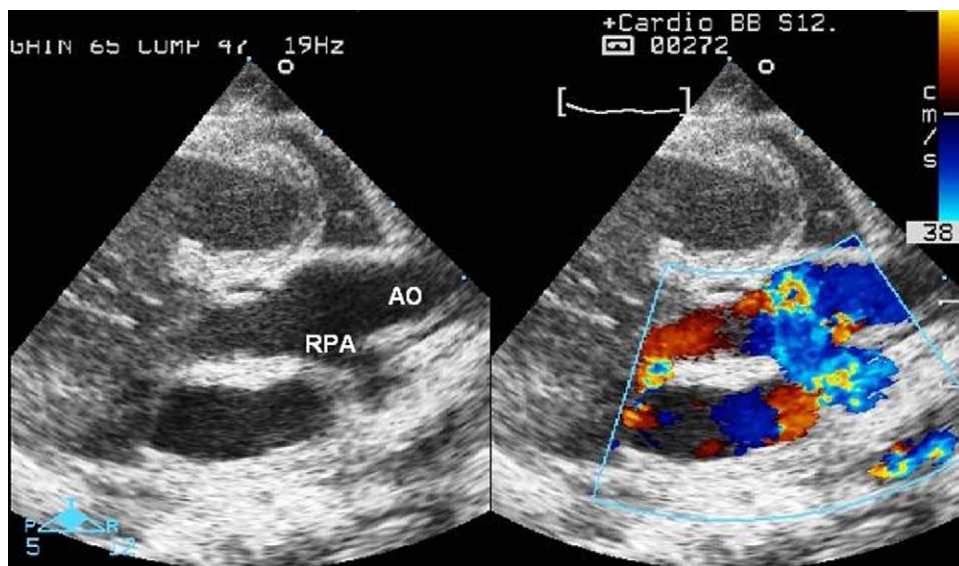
Parasternal long-axis view without (left) and with colour Doppler (right). The right pulmonary artery arises from the posterior wall of the aorta. The colour Doppler scan shows the massive shunt into the right pulmonary branch. Ao: aorta; RPA: right pulmonary artery (Supplementary data).
